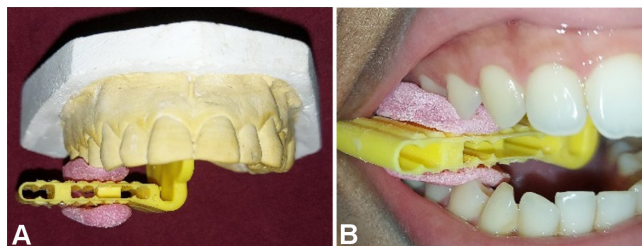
Fabrication of an acrylic stent for the standardization of radiographs A. Acrylic stent fabricated on the cast model; B. Placement of the stent in the oral cavity.
